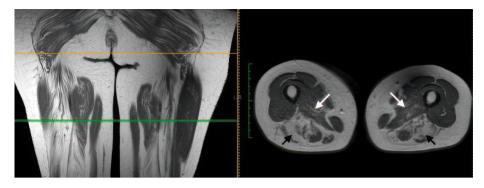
Results of MRI of soft tissues of the thighs of patient A. (T1-weighted, frontal and axial slices).
